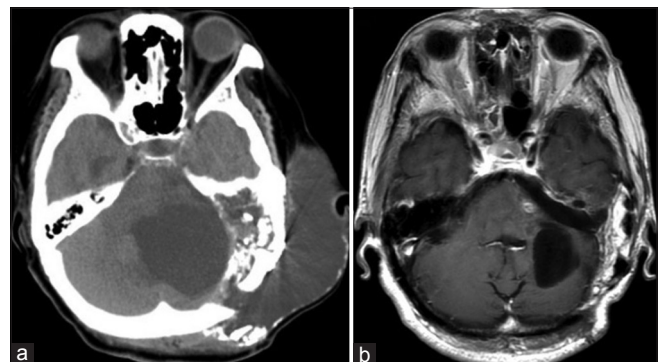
(a) One month later after operation, the axial brain CT showed a large left cerebellar cyst that communicated with a pseudomeningocele and severely compressed the brain stem. (b) The axial T1-weighted enhanced image of brain MRI showed a smaller cerebellar cyst after pseudomeningocele repair
